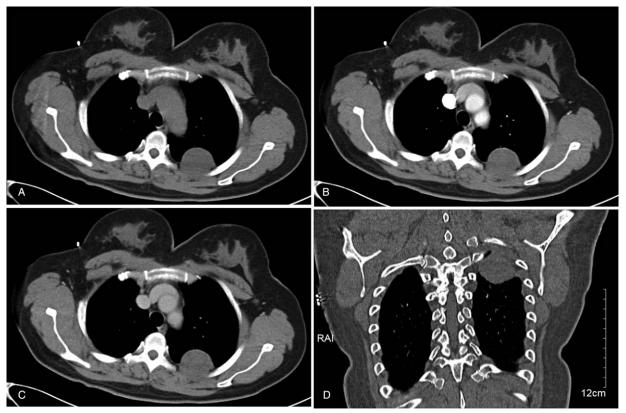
The CT scan shows a large heterogeneous mass locating at the left dorsal pleura. A: It shows low density before contrast, and the boundary is clear. B and C: After contrast, the mass shows slight heterogeneous enhancement with no obvious necrosis. D: Coronal position of chest CT shows the mass under the left dorsal pleura. CT = computerized tomogram.
